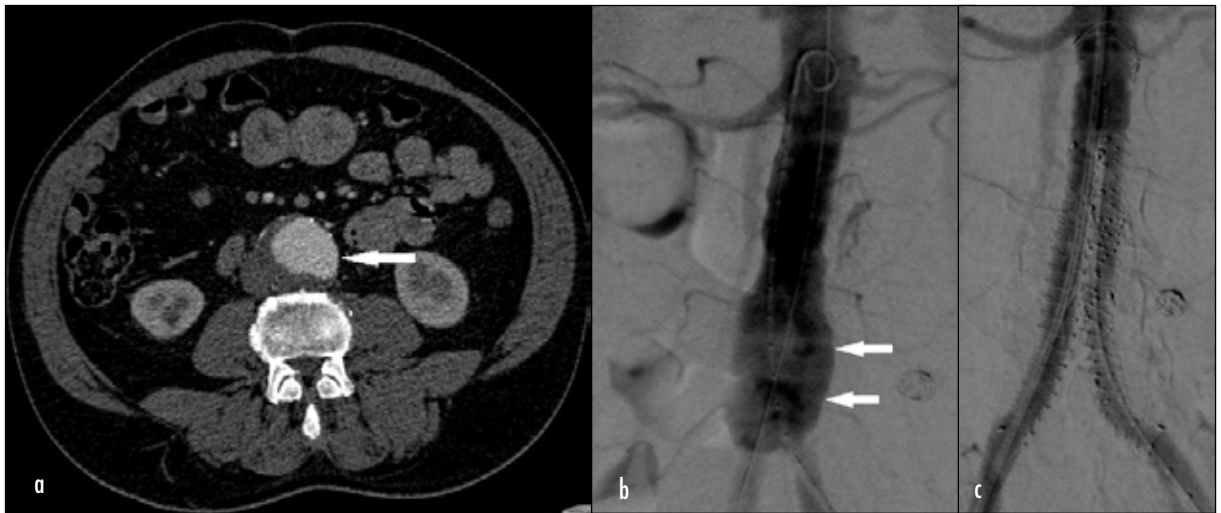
a. Axial contrast-enhanced computed tomography scan of the aorta showing an infrarenal abdominal aortic aneurysm (arrow). b. Pre-procedural angiogram of the aorta demonstrating the aortic aneurysm (arrows). c. Post-procedural angiogram of the aorta with the stent graft within the aorta and limbs of the graft within the common iliac arteries. Contrast demonstrates preferential flow down the stent graft.
